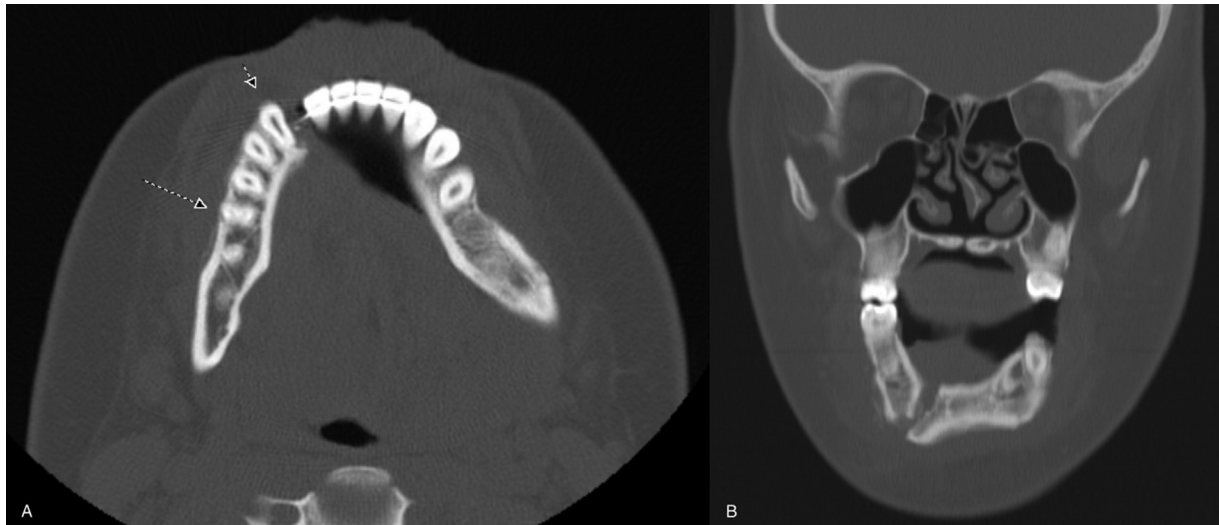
Axial (A) and coronal (B) computed tomography images show right parasymphyseal mandibular fracture extending just lateral to right lateral incisor.
